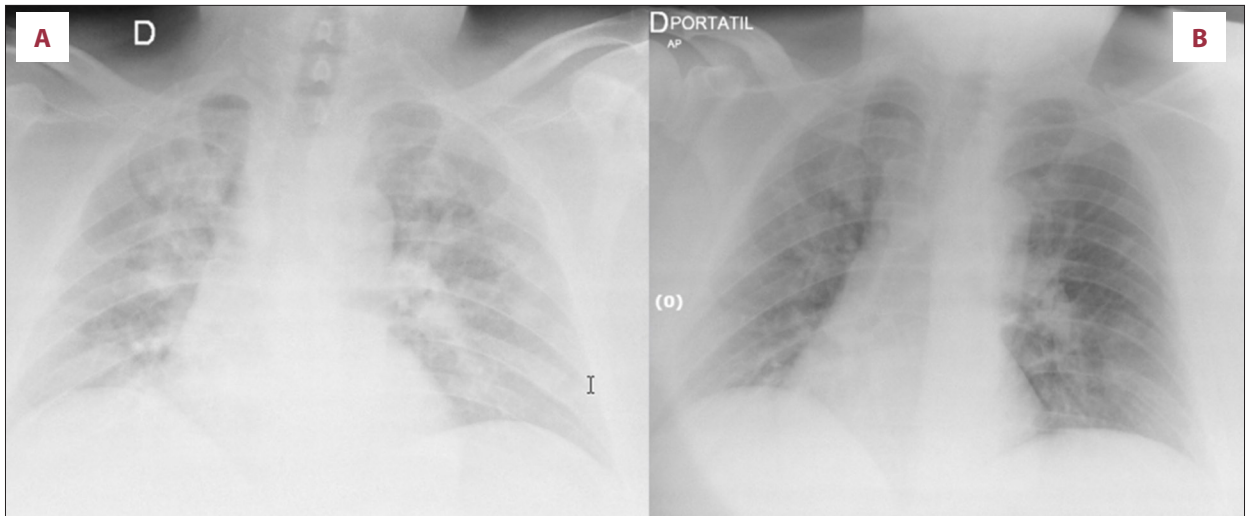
Chest X-ray before (A) and after only 2 sessions of oxygen–ozone therapy (B).
